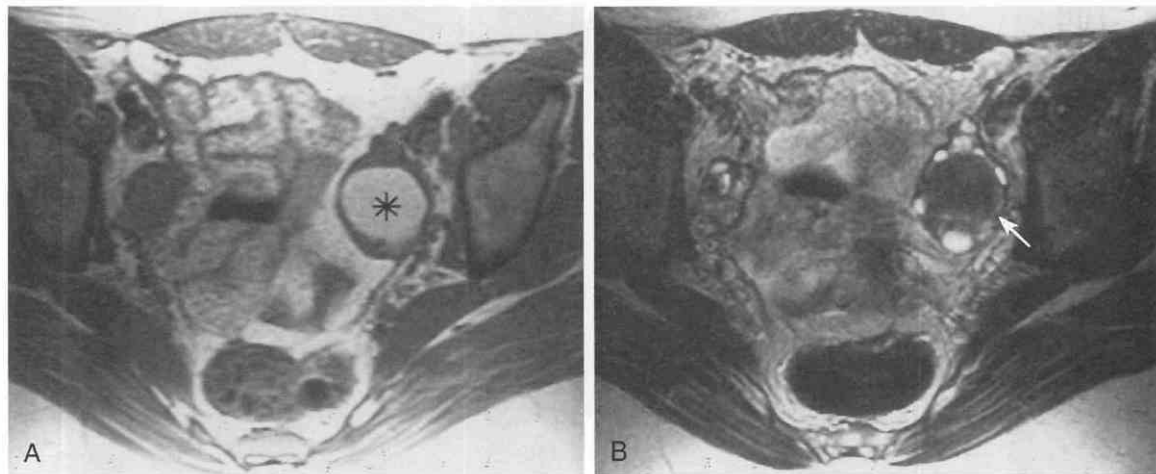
Ovarian endometrioma. *A*, Axial T1-weighted spin-echo image (TR = 600 msec, TE = 12 msec) through the ovaries show a high-signal-intensity mass of the left adnexa (asterisk). *B*, T2-weighted fast spin-echo image (TR = 4000 msec, TE_{eff} = 140 msec; acquisition matrix = 256 × 256; field of view = 22 cm; slice thickness = 5 mm) shows marked low signal intensity (shading) within the mass (arrow), characteristic of an endometrioma. Several high-signal-intensity ovarian follicular cysts surround the mass, indicating its location within the ovary. TE_{eff}, effective echo time.
